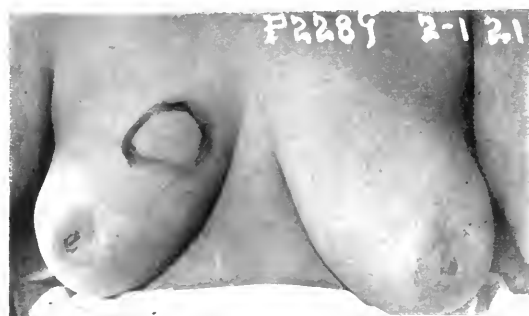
Case 3. Carcinoma in upper inner quadrant with some evidence of mediastinal disease in a woman of seventy-one years of age, which has entirely disappeared under x-ray and radium treatment. Duration of the disease, two years. Finished photograph not yet made.
